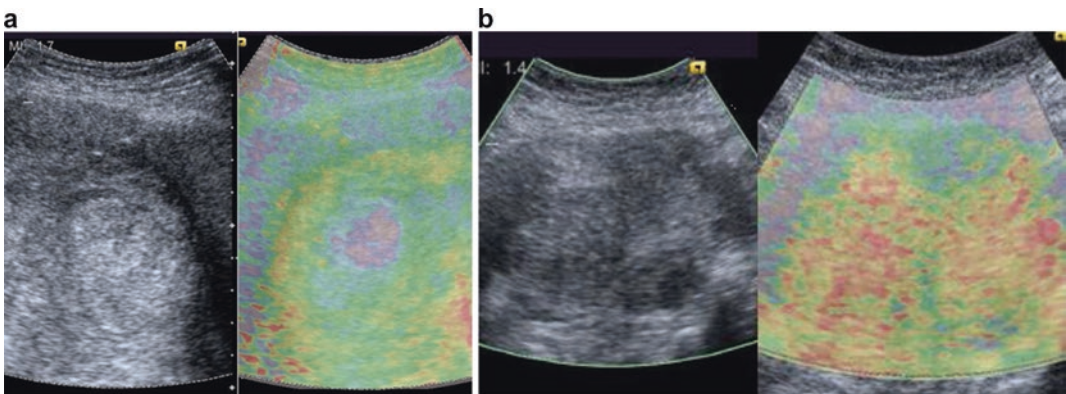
Ultrasound images of uterine leiomyosarcoma (a) and leiomyoma (b). *Left:* Ultrasound B-mode image. *Right:* Acoustic radiation force impulse (ARFI) image. Irregular distribution of blue, yellow, green, and red was
